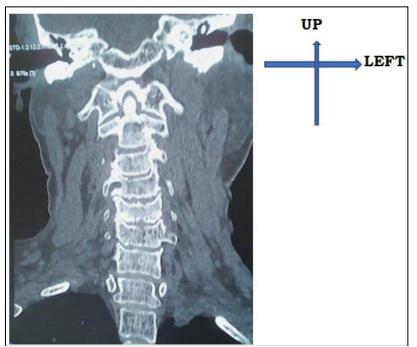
CT of the cervical spine (coronal reconstruction)
